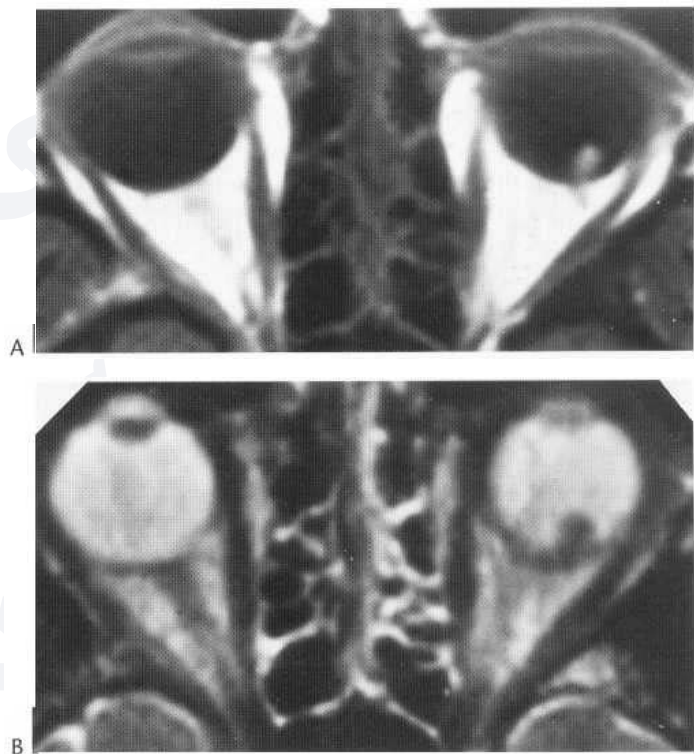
Choroidal melanoma. T₁- (A) and T₂-weighted (B) MR images demonstrate well-circumscribed broad based lesion of posterior left retina. High signal intensity on T₁-weighted images and low signal intensity on T₂-weighted images is due to characteristic paramagnetic effect of melanin.
